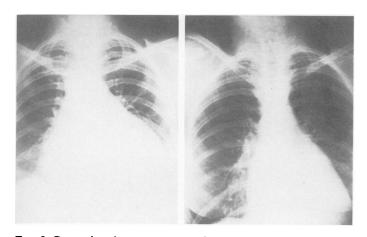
Comparison between preoperative chest Xray and Xray taken 6 months following endocardiectomy (Case 3).
